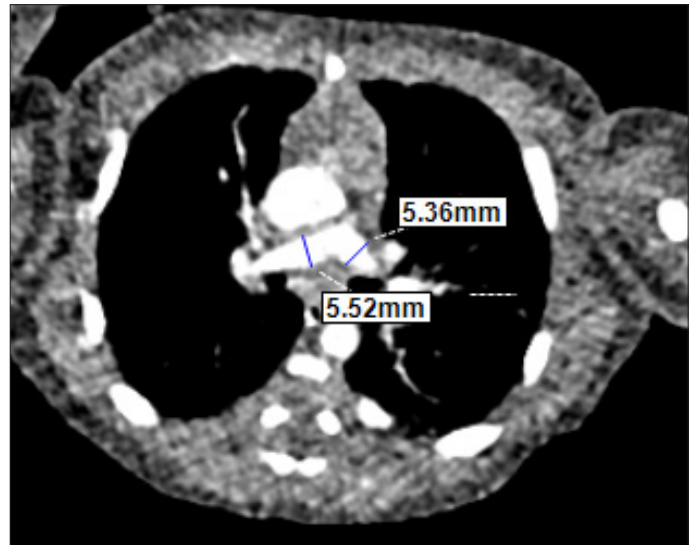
Thoracic computed tomography angiography showing the hypoplastic left and right pulmonary arterial branches. McGoon index 1.69
